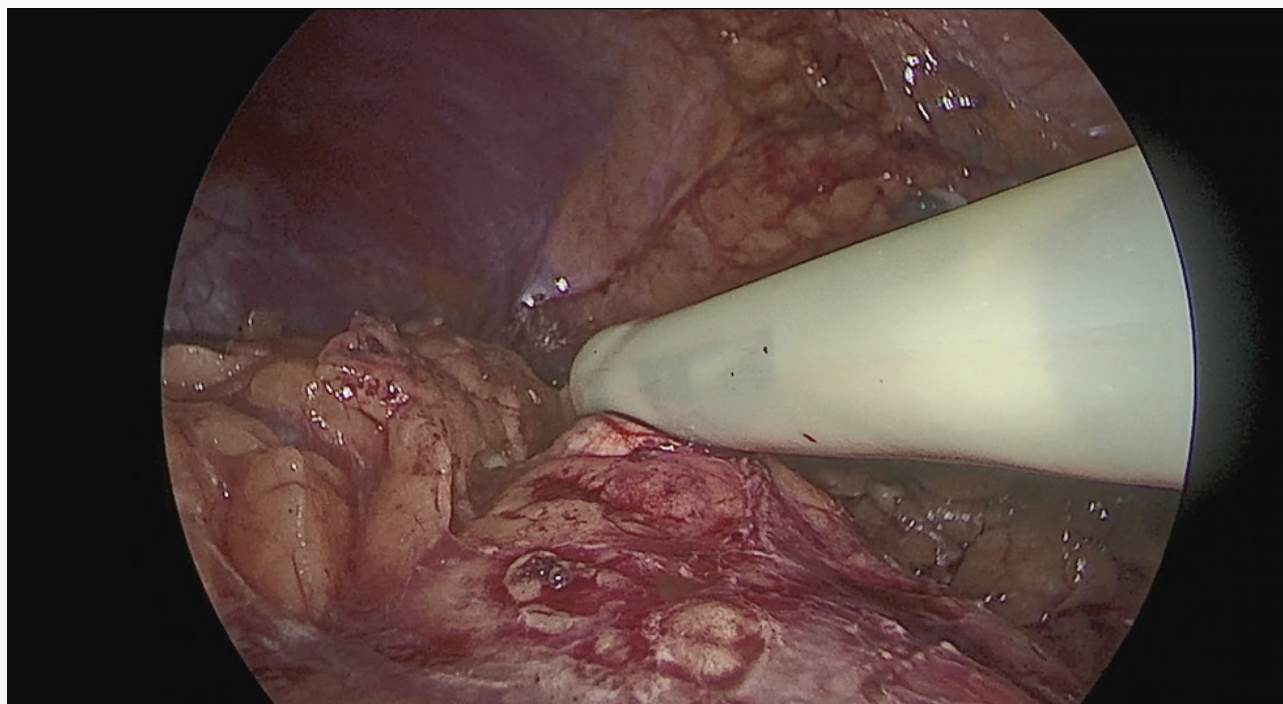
Intraoperative ultrasound
